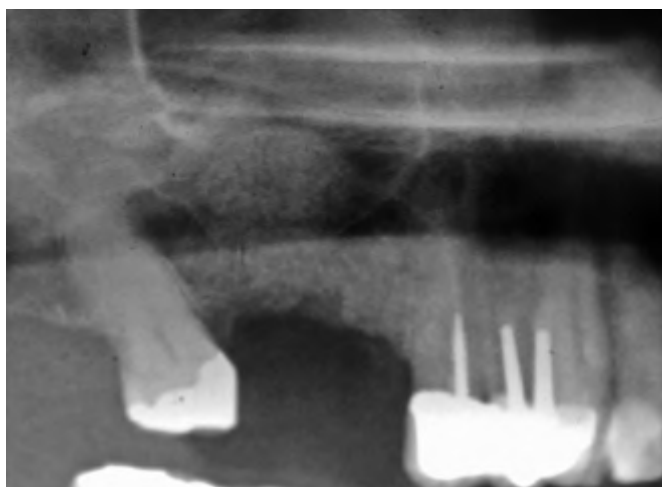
Radiograph of the same patient after bone was grafted into the floor of the sinus. This effectively increased the quantity of bone, which made it possible to place two implants into this quadrant.
